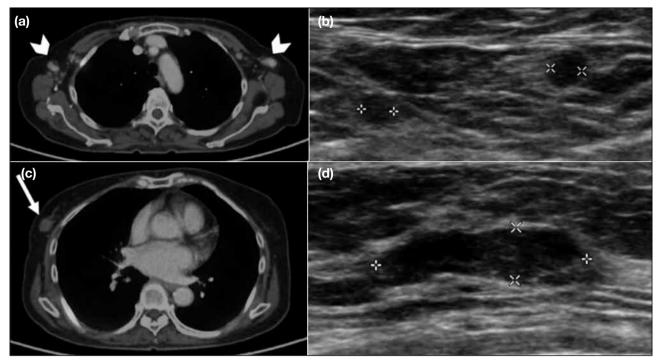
¹⁸F-fluorodeoxyglucose (FDG) positron emission tomography/computed tomography (PET/CT) images and corresponding ultrasonograms from a patient presenting with bone pain and weight loss. (a) PET/CT scans through the axillae reveal multiple prominent bilateral axillary lymph nodes with hypermetabolism (SUVmax 3.6) (arrowheads). (b) Ultrasonogram showing suspicious lymph nodes with loss of fatty hila, which were targeted for fine needle aspiration. Cytology confirmed reactive lymph nodes. (c) PET/CT images show a non-hypermetabolic (SUVmax 1.0) breast mass in the upper outer quadrant of the right breast on (arrow). (d) Ultrasonogram showing a mildly irregular hypoechoic mass corresponding to the lesion on PET/CT. Biopsy revealed a fibroadenoma.
